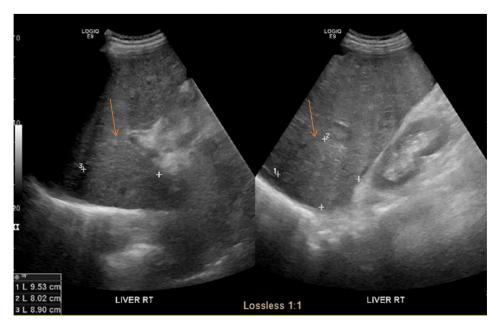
Repeat right upper quadrant ultrasound revealing right hepatic lobe mass (arrow).
